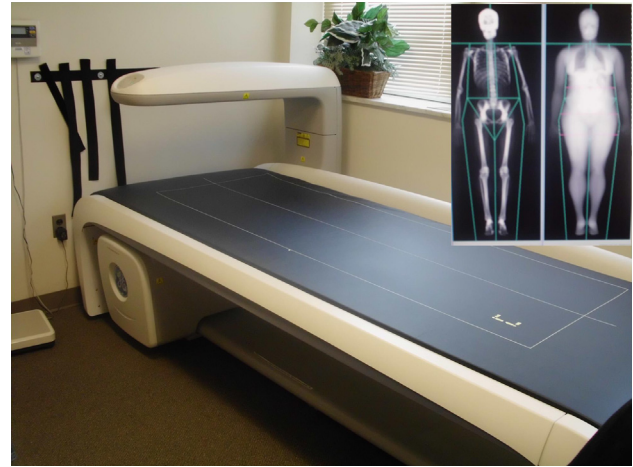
Dual-energy x-ray absorptiometer for body composition.
